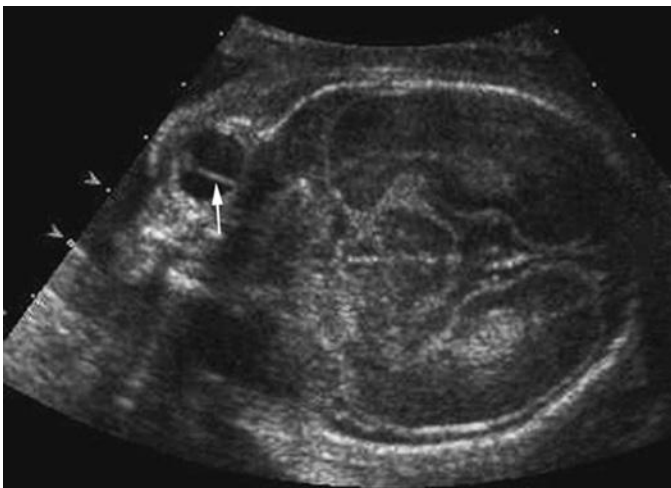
The hyaloid artery (*arrow*) can often be seen in the second trimester. It disappears between 23 and 28 weeks of gestation and is normally not visible by ultrasound after 29 weeks of gestation.
